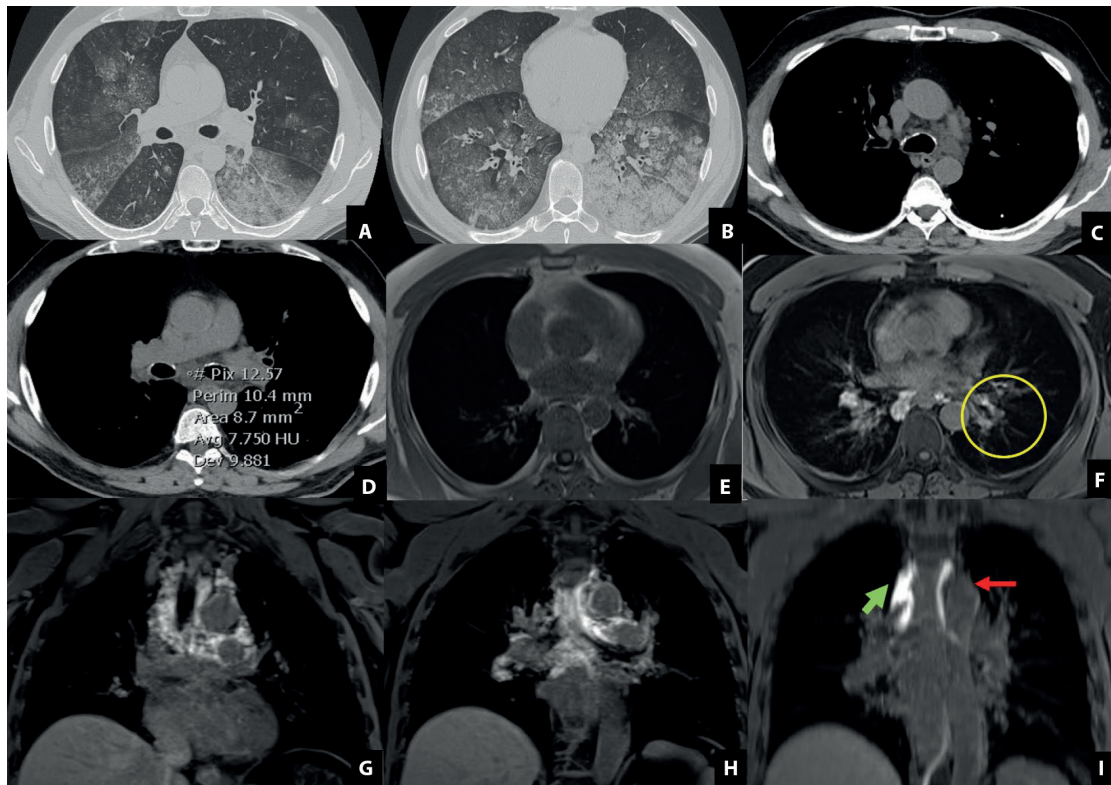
CT scan (a-d) shows extensive bilateral ground glass attenuation and crazy paving pattern, associated with consolidation in the left lower lobe. Diffuse thickening of the bronchial wall is also present (a-b). In the mediastinal window (c,d) multiple nodular structures with fluid density (d) are present in all the mediastinal and hilar stations. MRI T1-weighted sequence before contrast (e). T1-w after injection of contrast medium (f-i) shows high signal in all the mediastinal structures. The peribronchovascular interstitium is also diffusely thickened, more than in the pre-contrast images (f, yellow circle), and has high signal related to an inverted direction of the lymphatic drainage (g-h). Coronal T1-w MIP reconstruction after 1 hour since the contrast administration, shows high signal in the thoracic duct (f, red arrow). Partial opacification of the azygos system (red arrows).
